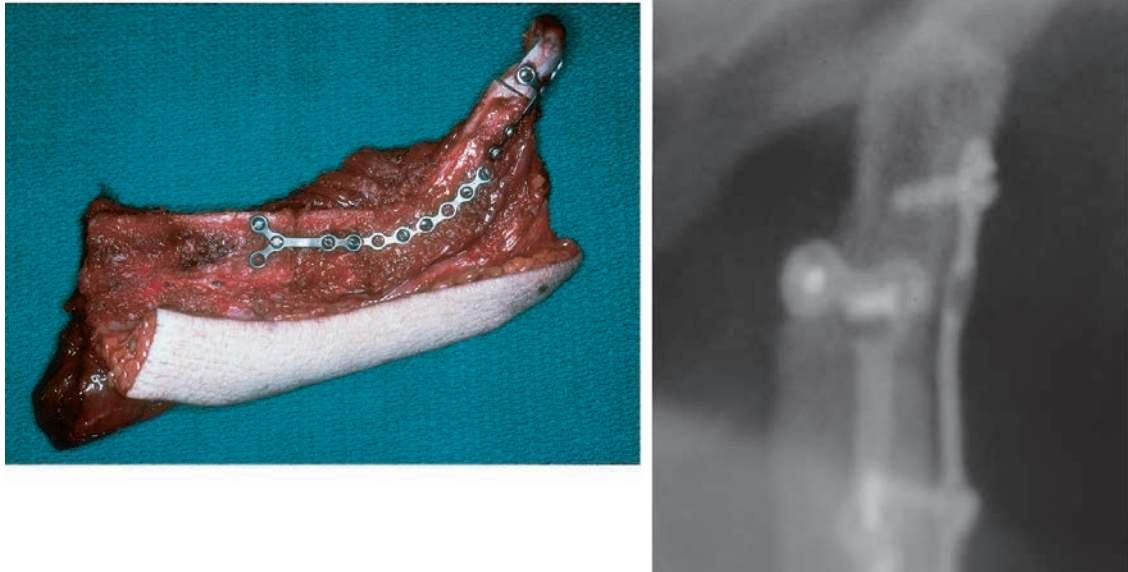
(Left) This patient's completed fibula free-flap graft is shown before inseting with the transplanted condyle in place. (Right) Close-up Panorex view at long-term follow-up shows condyle graft condition. Comparison of miniplate and screw landmarks on radiography with adjacent flap view verifies complete survival of the condyle graft.
